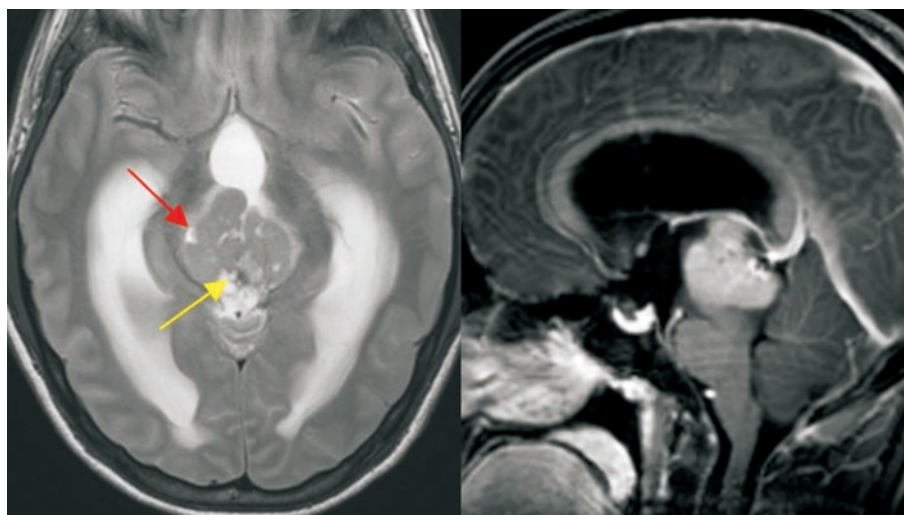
Urgent magnetic resonance imaging shows that the pineal gland tumour had increased in size. Axial and sagittal T2 MRI exhibits isointense to grey matter with areas of cyst formation shown by red arrow. Low signal intensity in the posterior part of the mass represents calcification shown by yellow arrows. The pineal gland tumour compressed the aqueduct of Sylvius causing hydrocephalus. The MRI features suggested of germinoma.
